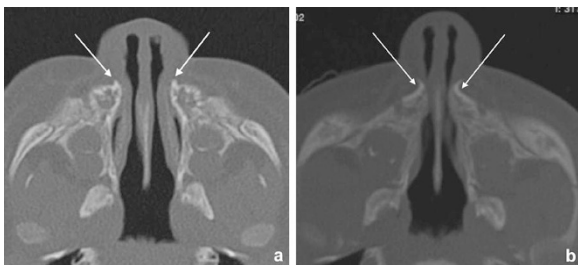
Axial Computed Tomography slice at the level of the maxillary bone (A) Normal pattern with a wide bilateral nasal pyriform aperture (arrows). (B) Congenital nasal pyriform aperture stenosis (arrows).
